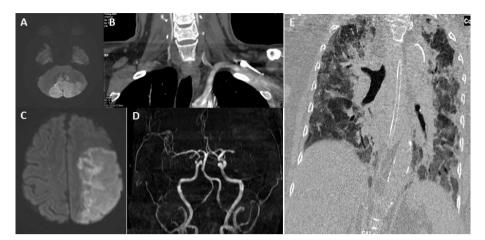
MR brain diffusion-weighted axial image (A) showing cerebellar infarct due to acute thrombus in left subclavian artery extending into left vertebral as shown in CT angiogram coronal sections (B); MR brain diffusion-weighted axial image showing left MCA territory infarct (C) due to left distal M2 Middle cerebral artery thrombotic occlusion shown in 3D time-of-flight image (D). HRCT chest coronal image of the same patient showing extensive bilateral ground-glass opacities (E).
